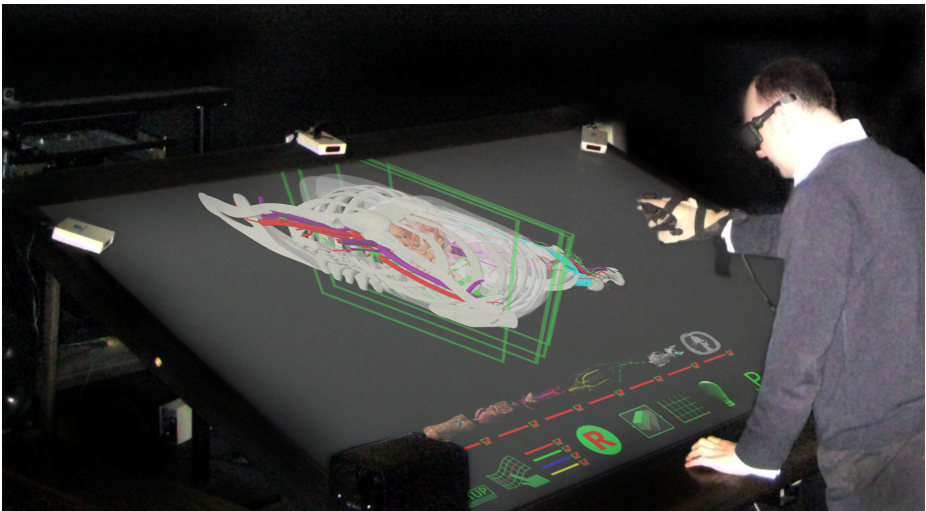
Investigation of CT data through VR during the user-trials
